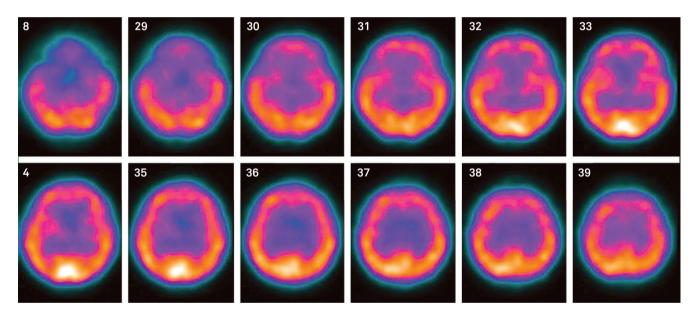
Technetium SPECT showing symmetrical frontal lobe and midbrain hypoperfusion.
